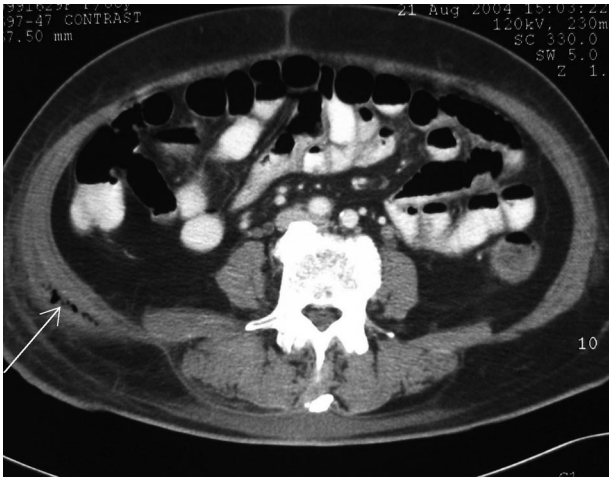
Computed tomographic scan of the abdomen showing deep fascial thickening, swelling of the subcutaneous tissue, and fluid and gas (arrow) in soft tissue of the abdominal wall, features consistent with abdominal wall necrotizing fasciitis.
